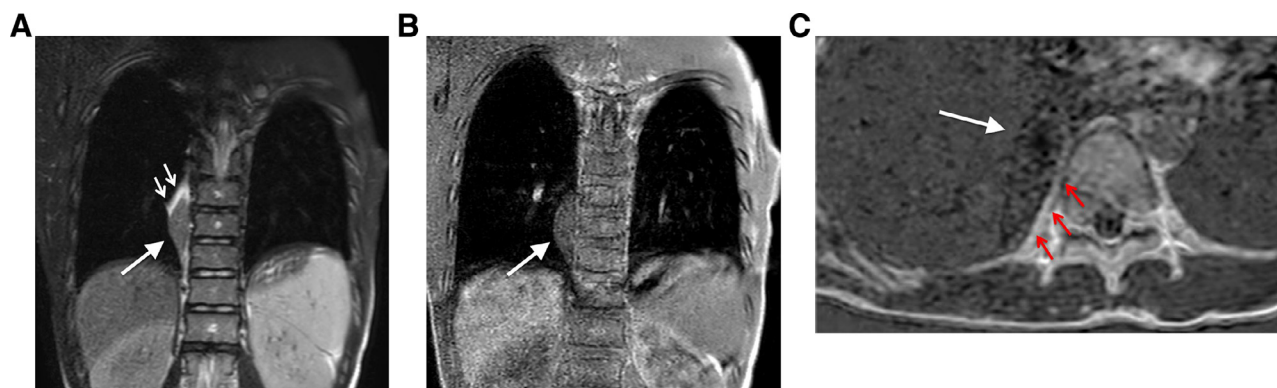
MR images obtained at a 1.5 T clinical unit.
